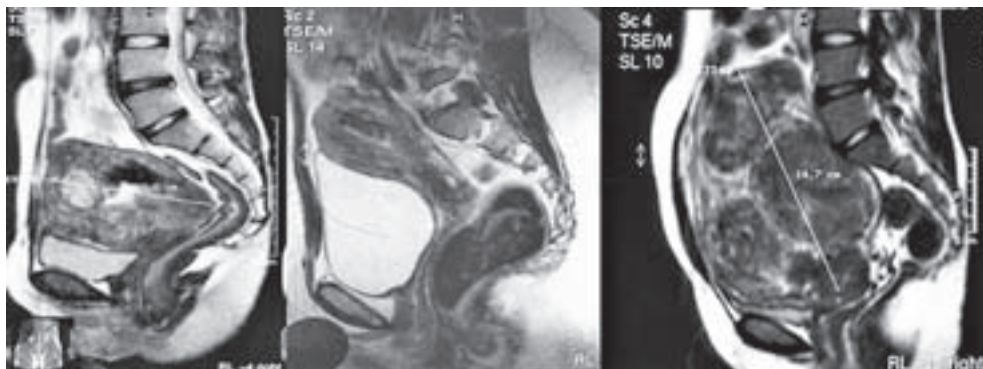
MRI pictures, sagittal view. The patient with fibroid uterus pressing and displacing the urinary bladder down, but the internal urethral sphincter is still intact, with no leakage of urine.
